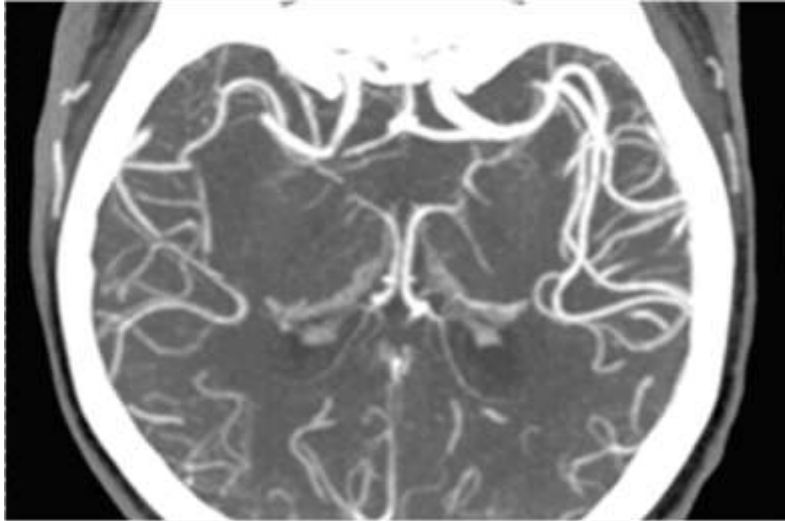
CTA of intracranial vessels reveals the occlusion of the upper branch of dichotomization of the right middle cerebral artery.
